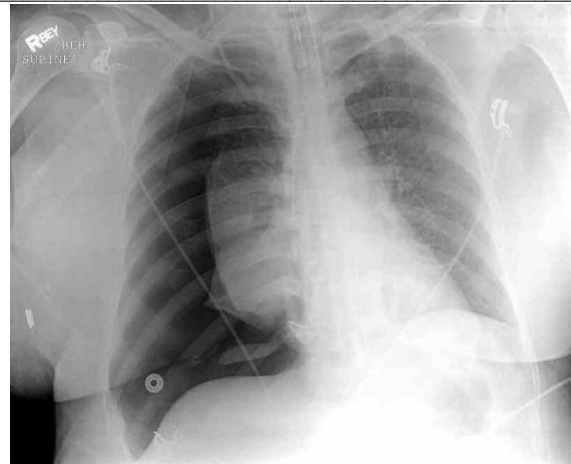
Right Tension Pneumothorax Radiography.
